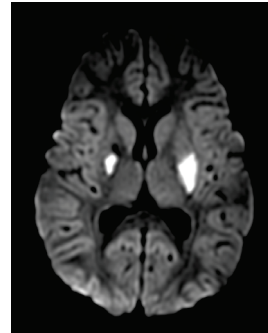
Bilateral basal ganglia infarct in DWI
